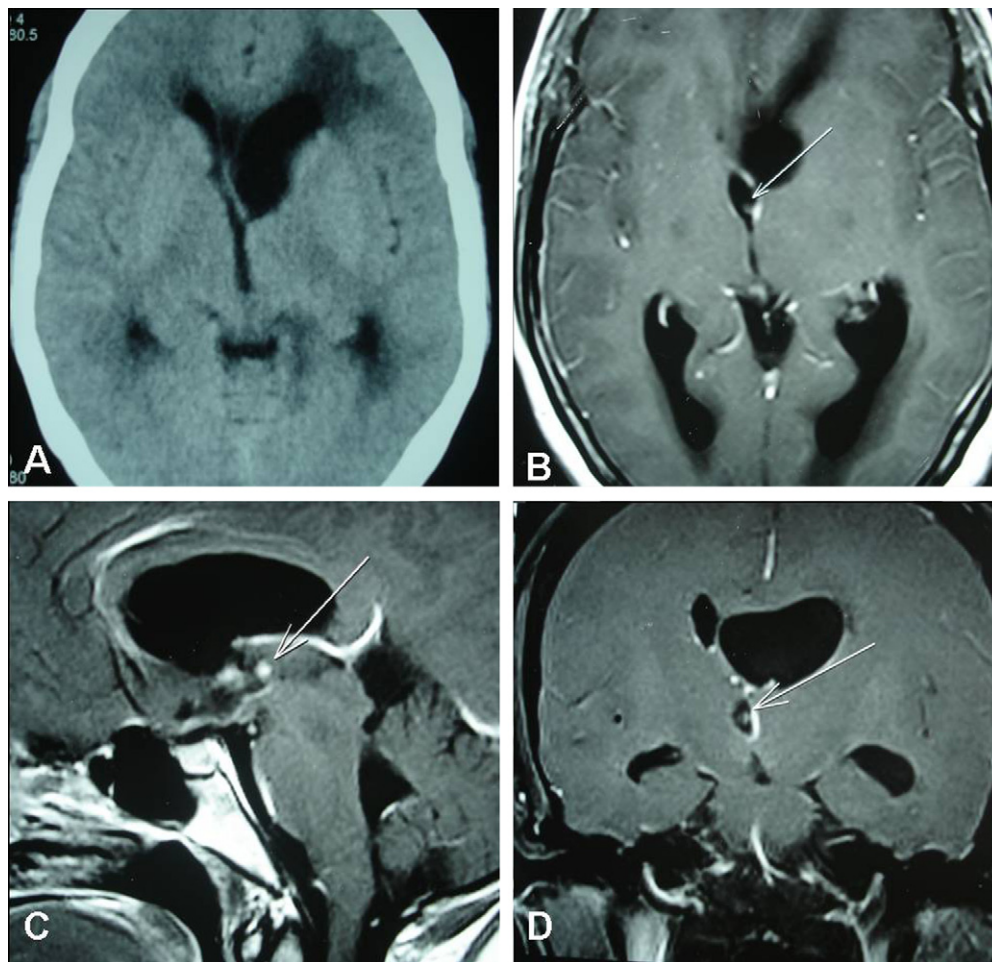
Non-contrast axial CT scan of the head (A) showing asymmetric dilatation of the left lateral ventricle as a result of obstruction of the foramen of Monro by a third ventricular cyst. Axial (B), sagittal (C) and coronal (D) contrast-enhanced MRI sections of brain showing a third ventricular cyst with the scolex (white arrows) causing asymmetrical hydrocephalus.
